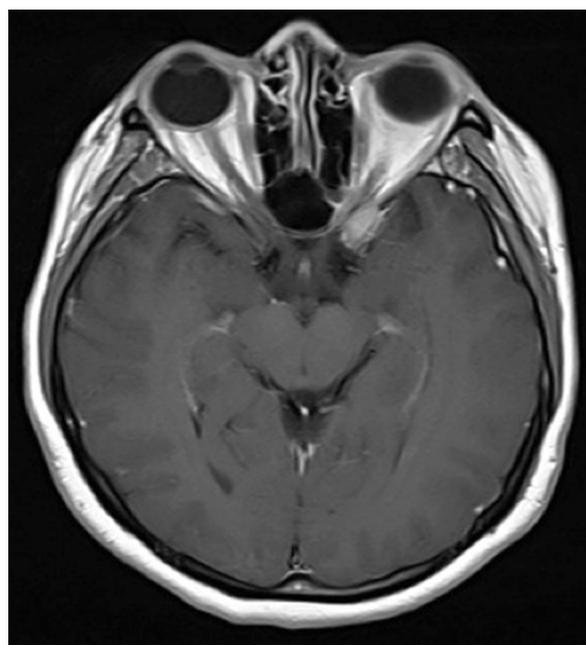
Gadolinium-enhanced T2-weighted magnetic resonance image showing a soft tissue lesion at the left orbital apex involving the intracallicular portion of the left optic nerve.
